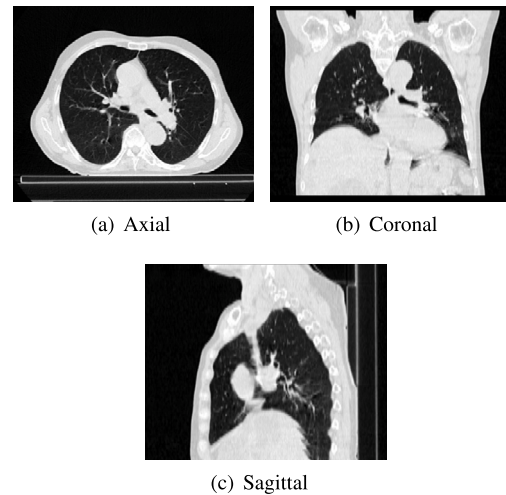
Thoracic CT images in different planes [121].
